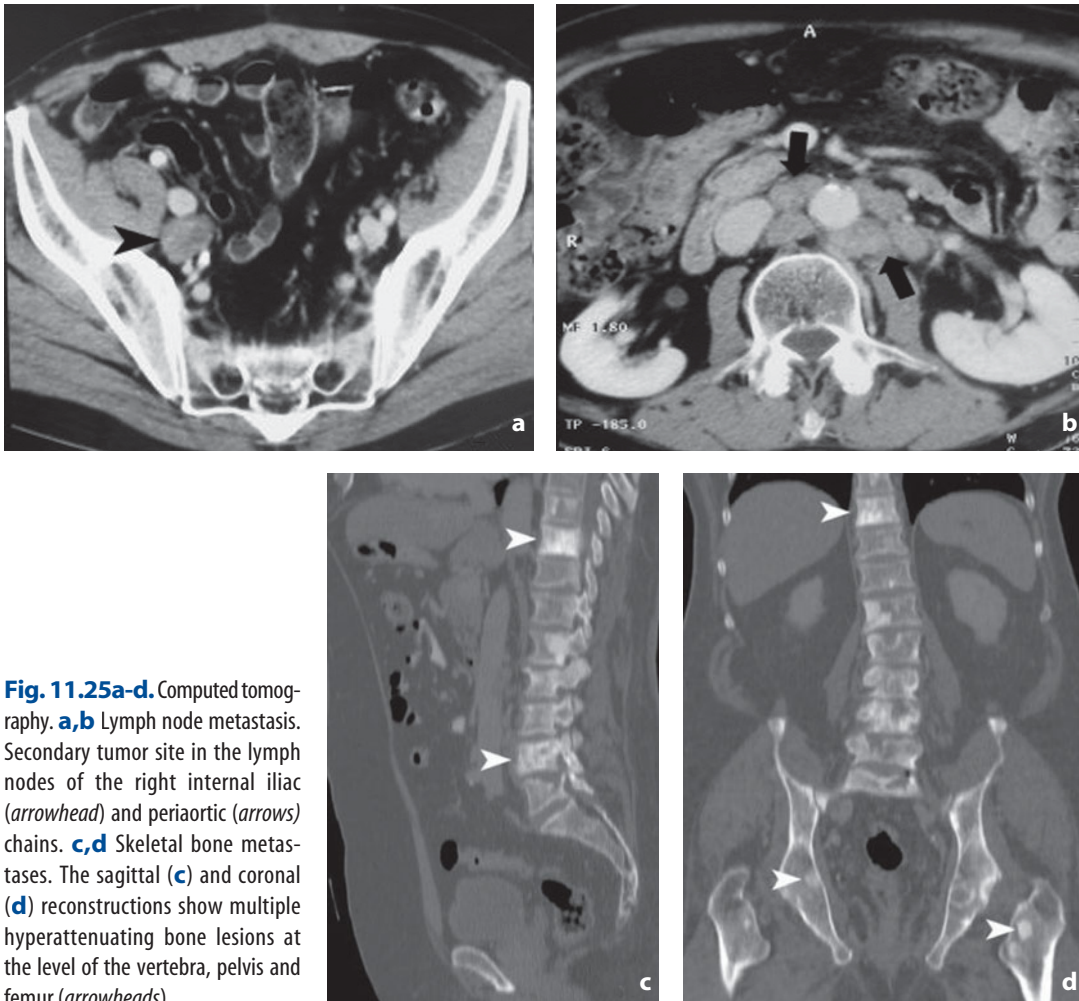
Computed tomography. a,b Lymph node metastasis. Secondary tumor site in the lymph nodes of the right internal iliac (*arrowhead*) and periaortic (*arrows*) chains. c,d Skeletal bone metastases. The sagittal (c) and coronal (d) reconstructions show multiple hyperattenuating bone lesions at the level of the vertebra, pelvis and femur (*arrowheads*)
